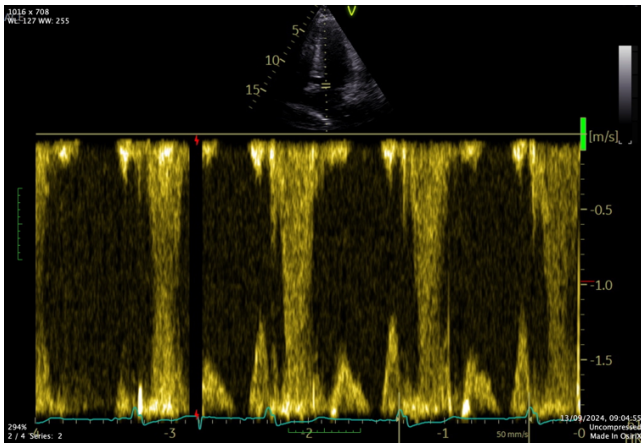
Echocardiography post normalization function showing high velocities in LVOT
